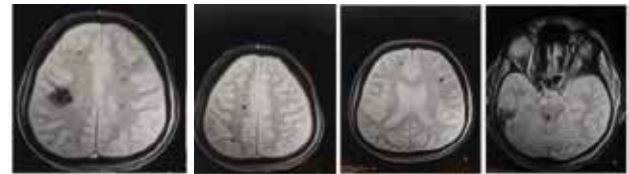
MRI showing multiple areas of signal void in cerebral hemispheres and pons suggestive of areas of hemorrhage or calcification
